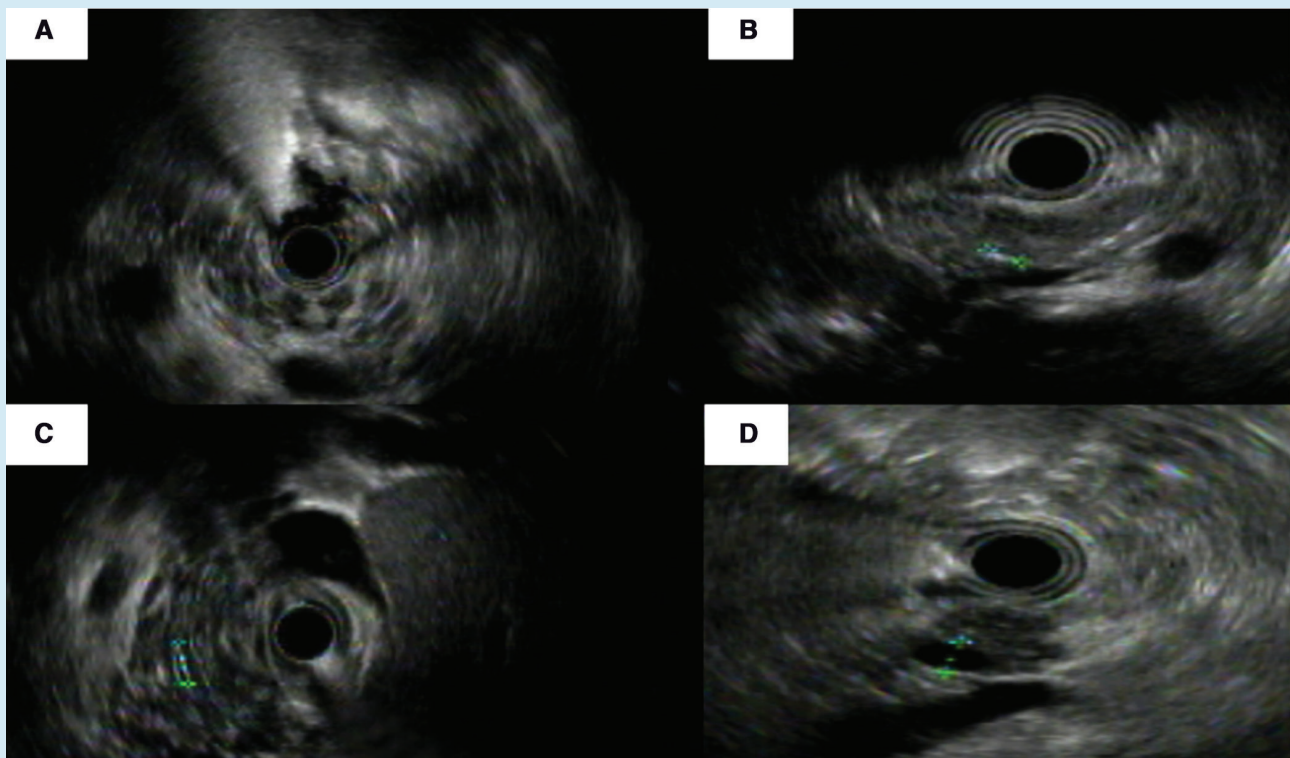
Endoscopic ultrasonography findings of the patients. Hyperechoic strands (A), lobularity (B), hyperechoic duct wall (C) and dilatation of the main pancreatic duct (D).
